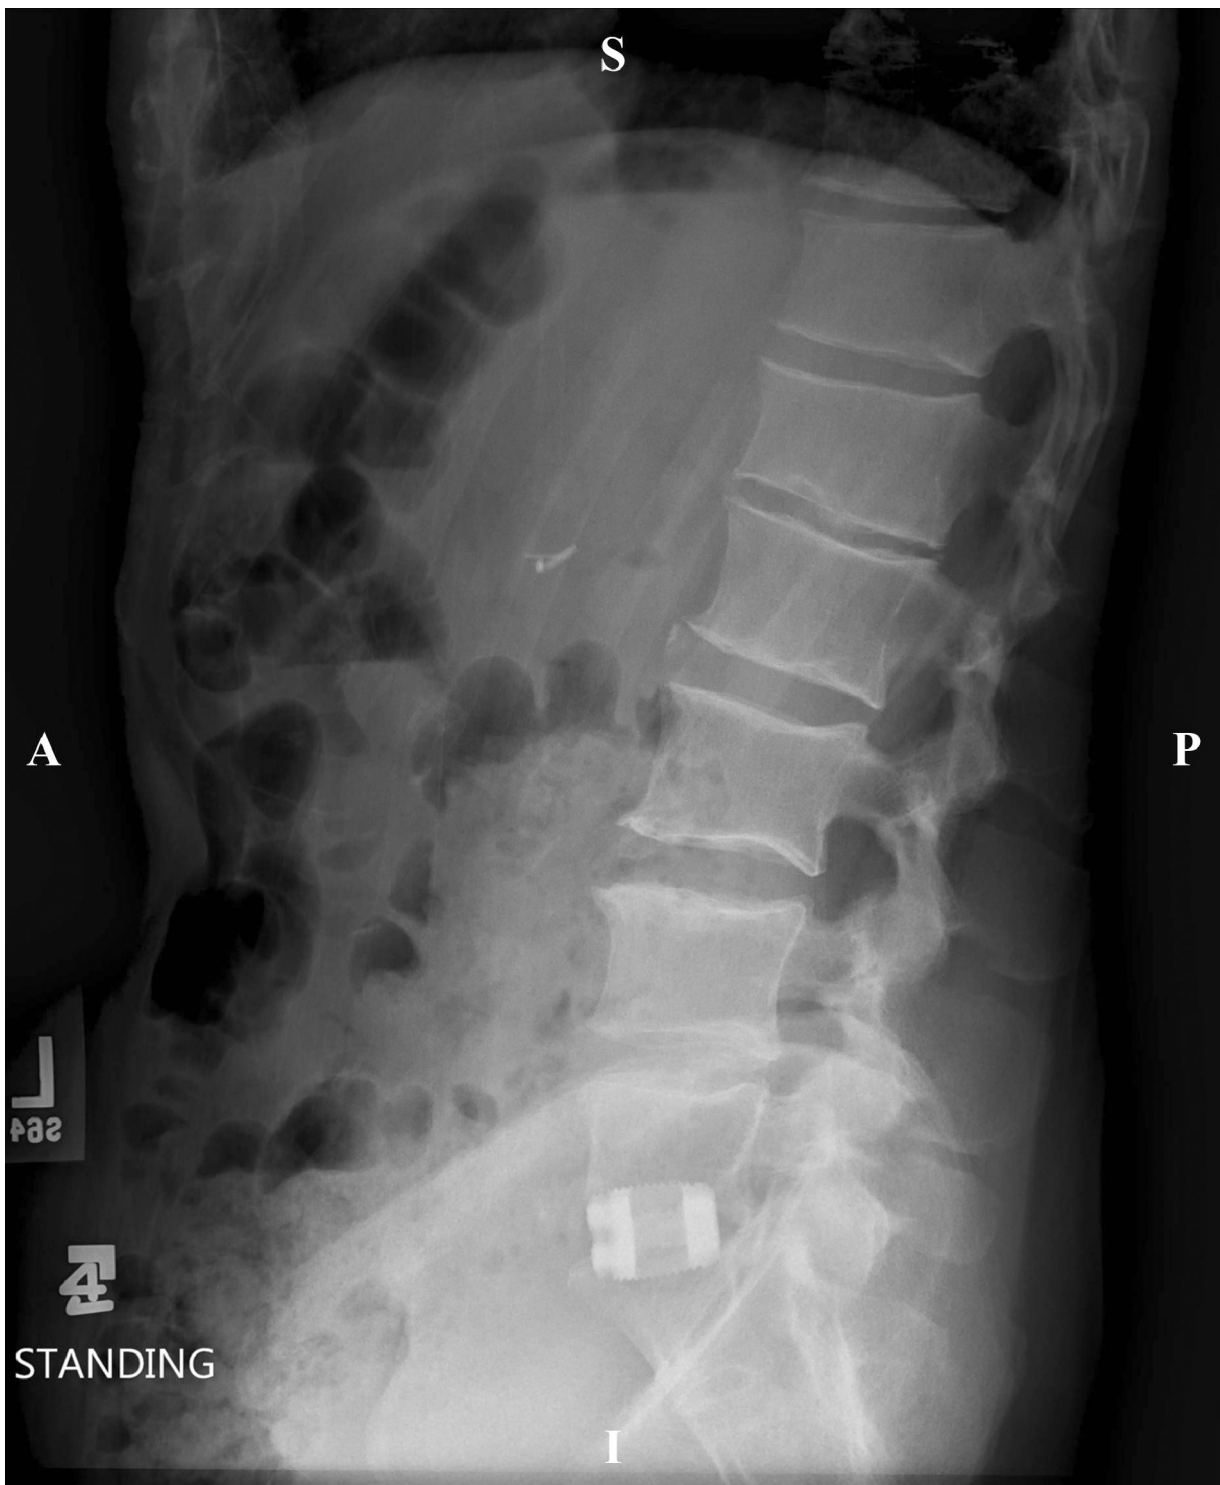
Case 1: Seven-month post-operative lateral X-ray image showed stabilization of the fused segments obtained by the Si_3N_4 interbody spacer without instrumentation. Note the radiographic visibility of the implant on this view.
